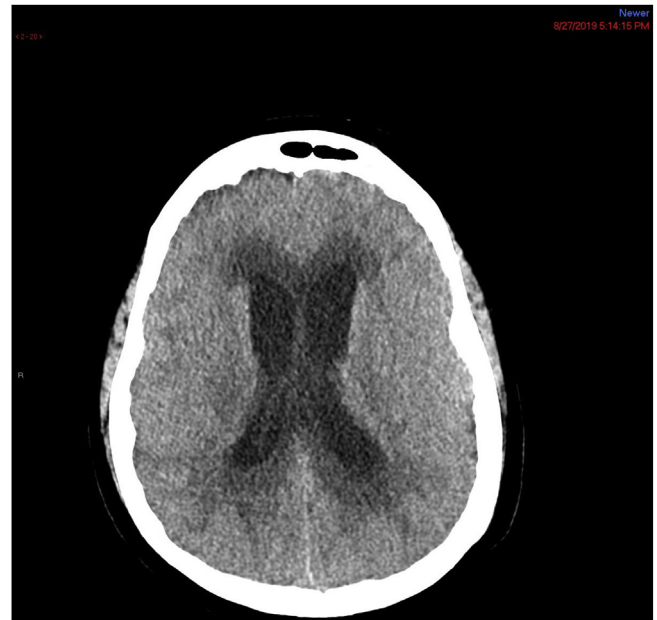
Non-contrast CT of head with diffuse ventriculomegaly and hydrocephalus of bilateral temporal horns.
